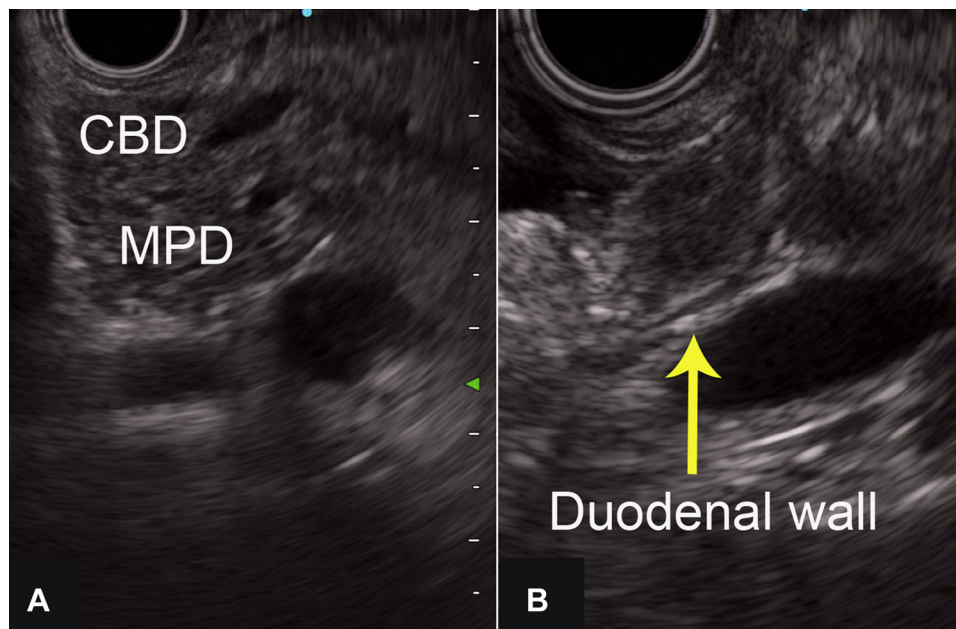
Endoscopic ultrasound image of an ampullary tumor showing no invasion into the common bile duct or main pancreatic duct (A) or duodenal wall (B, yellow arrow).
